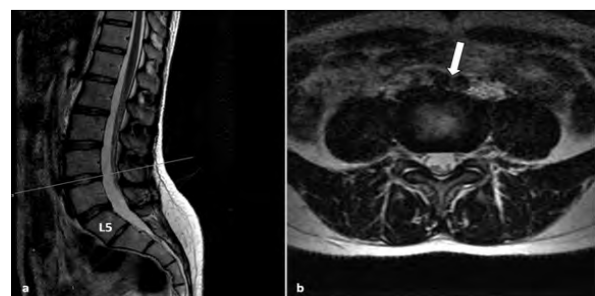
Sagittal T2-weighted MR image (a) of a LSTV patient, and corresponding axial T2-weighted MR image (b) passing through the L3-L4 intervertebral disc level at which the aortic bifurcation (arrow) is seen.
